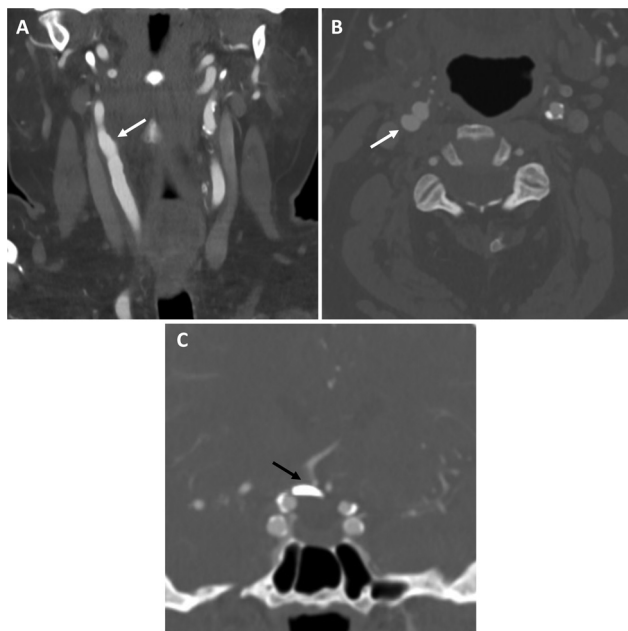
Follow-up imaging. The patient was treated successfully with a staged right carotid endarterectomy followed by microsurgical aneurysm clipping 5 days later. Follow-up CTA imaging demonstrated wide patency of the right ICA (white arrows on coronal [A] and axial [B] CTA) and no residual aneurysm (black arrow on coronal CTA [C]). CTA, computed tomography angiography; ICA, internal carotid artery.
